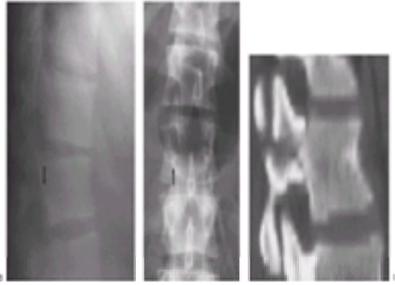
This 17-year-old girl was an unrestrained passenger in a school bus involved in a motor vehicle accident. The rear tire blew out at a speed of 70 mph, causing the bus to roll over several times. She was unconscious for a short period of time, but on arrival in the emergency department she complained of chest pain. Physical examination was pertinent for a sternal contusion, a nontender spine, and a normal neurologic examination of the lower extremities. Chest and spine radiographs demonstrated a fracture of T5. The lateral radiograph demonstrates a marked compression of T5 and kyphosis at T5–T6 (A). The anteroposterior radiograph demonstrates a compression of T5, with pedicular widening (B). The computed tomographic scan shows fractures of the laminae (C), along with retropulsion of bone into the canal (D). Due to the kyphosis, retropulsion of bone, and three-column injury, a posterior spinal fusion with distraction instrumentation was performed. Radiographs 1 year after surgery demonstrate correction of the kyphosis [lateral (E)] with a normal frontal alignment [anteroposterior (F)].
